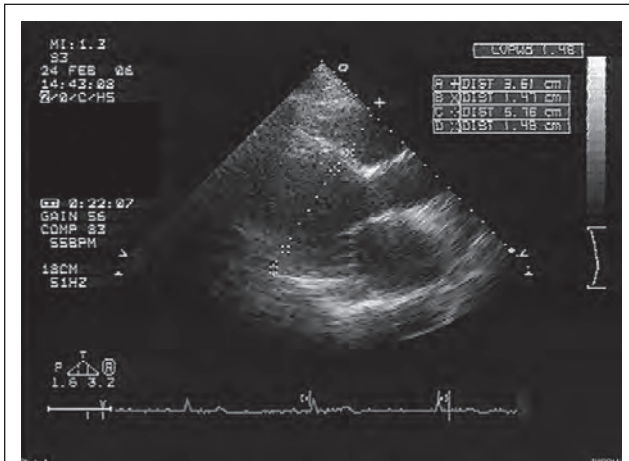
Two-dimensional transthoracic echocardiogram in parasternal long axis view obtained 1 month after discontinuation of phenytoin demonstrating near-normal left ventricular size (end diastolic diameter of 57.6 mm).
